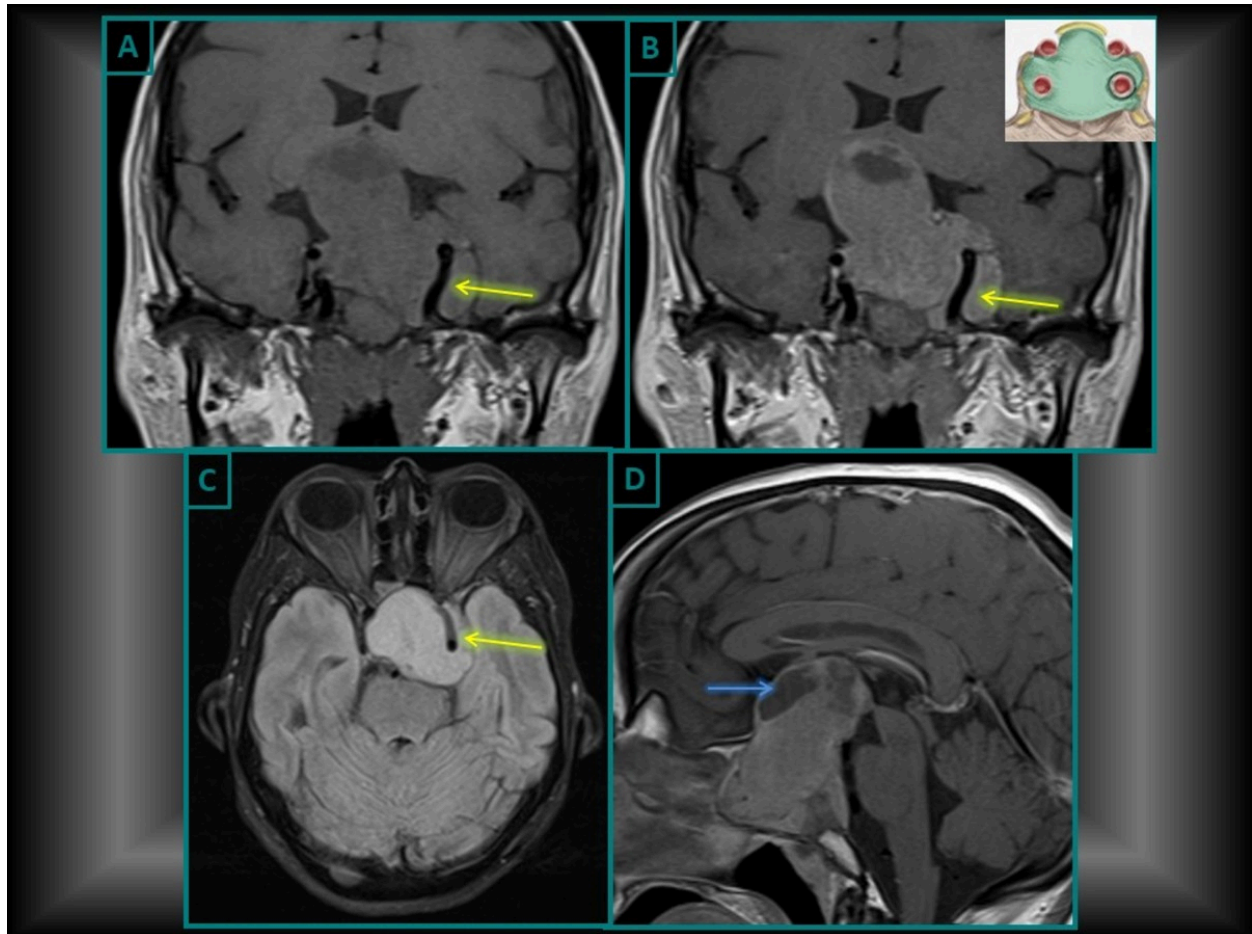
GIANT PITUITARY MACROADENOMA Grade 4: there is total encasement of the intracavernous carotid artery. Coronal T1-W (A) and T1-W post-contrast (B), Axial FLAIR (C) and sagittal T2-W images show an intensely enhancing mass lesion with peripheral cystic component (Blue arrow) in sellar and suprasellar location with a parasellar component on left side completely encasing the cavernous ICA (Yellow arrow) and extension into paranasal sinuses.
